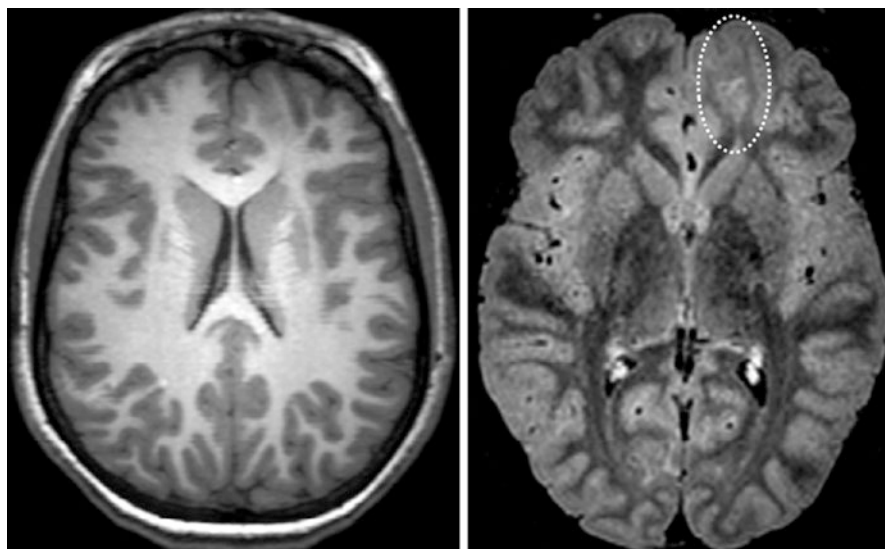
MRI of an 8-year-old girl with TSC and drug-resistant focal epilepsy. She presented with frequent seizures since the age of 19 months, including asymmetric infantile spasms, with a progressive developmental and language regression. The wide interictal epileptic focus on scalp EEG was anterior bifrontal and temporal, mainly left-sided. The EEG recording of the seizures oriented towards the left anterior frontal lobe but the corresponding clinical semiology was not consistent. This high-resolution MRI, including axial T1-weighted (*left*) and fluid-attenuated inversion recovery (FLAIR) (*right*) sequences, reveals a left anterior frontal lesion (*white dotted oval*), suspected to be mainly responsible for her seizures. The radiological aspect, including the transmantle sign, evokes a focal cortical dysplasia type 2
